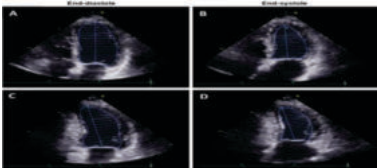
Modified Simpson's Method Echocardiography (Sources:www.mdpi.com)
